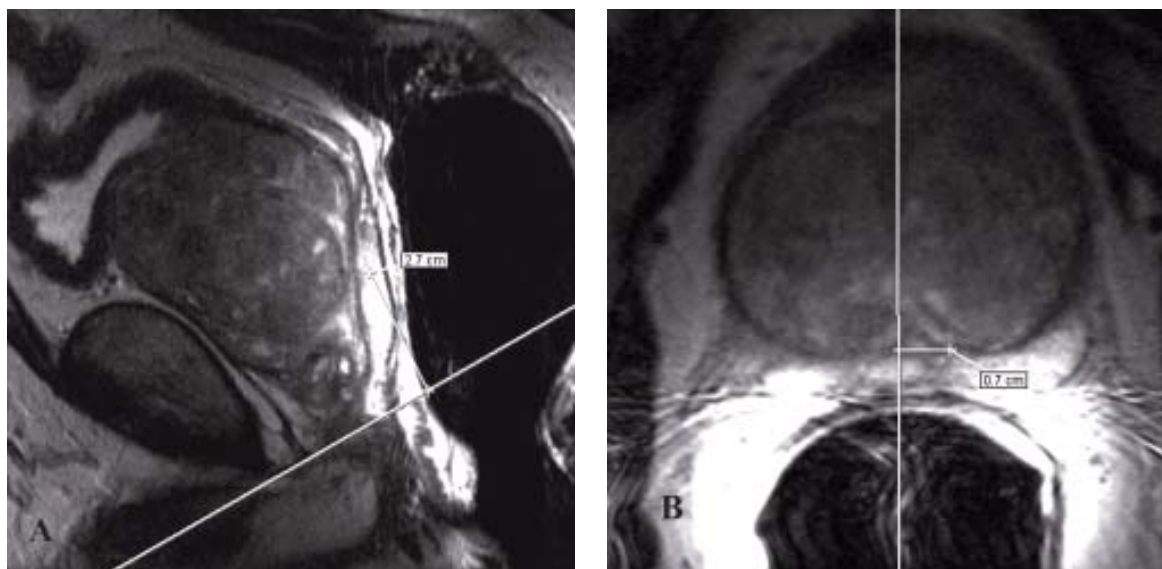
Showing the localization technique for landmark of MRI/MRSI guided TRUS-guided biopsy by measuring from the apex (A) and midline (B)
